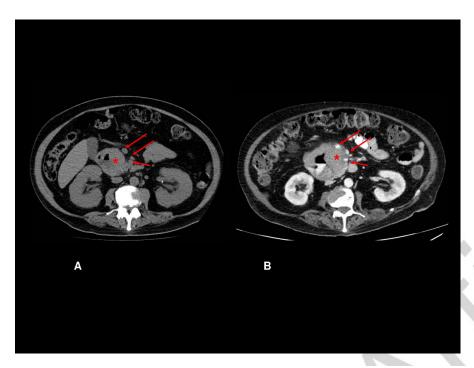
Computed tomography (CT) without contrast (A) and CT with intravenous contrast six months later (B). Axial sections are contrasted and image B shows an increase in the size of the tumor in the second part of the duodenum (asterisk), which encompasses the mesenteric veins (arrows).
